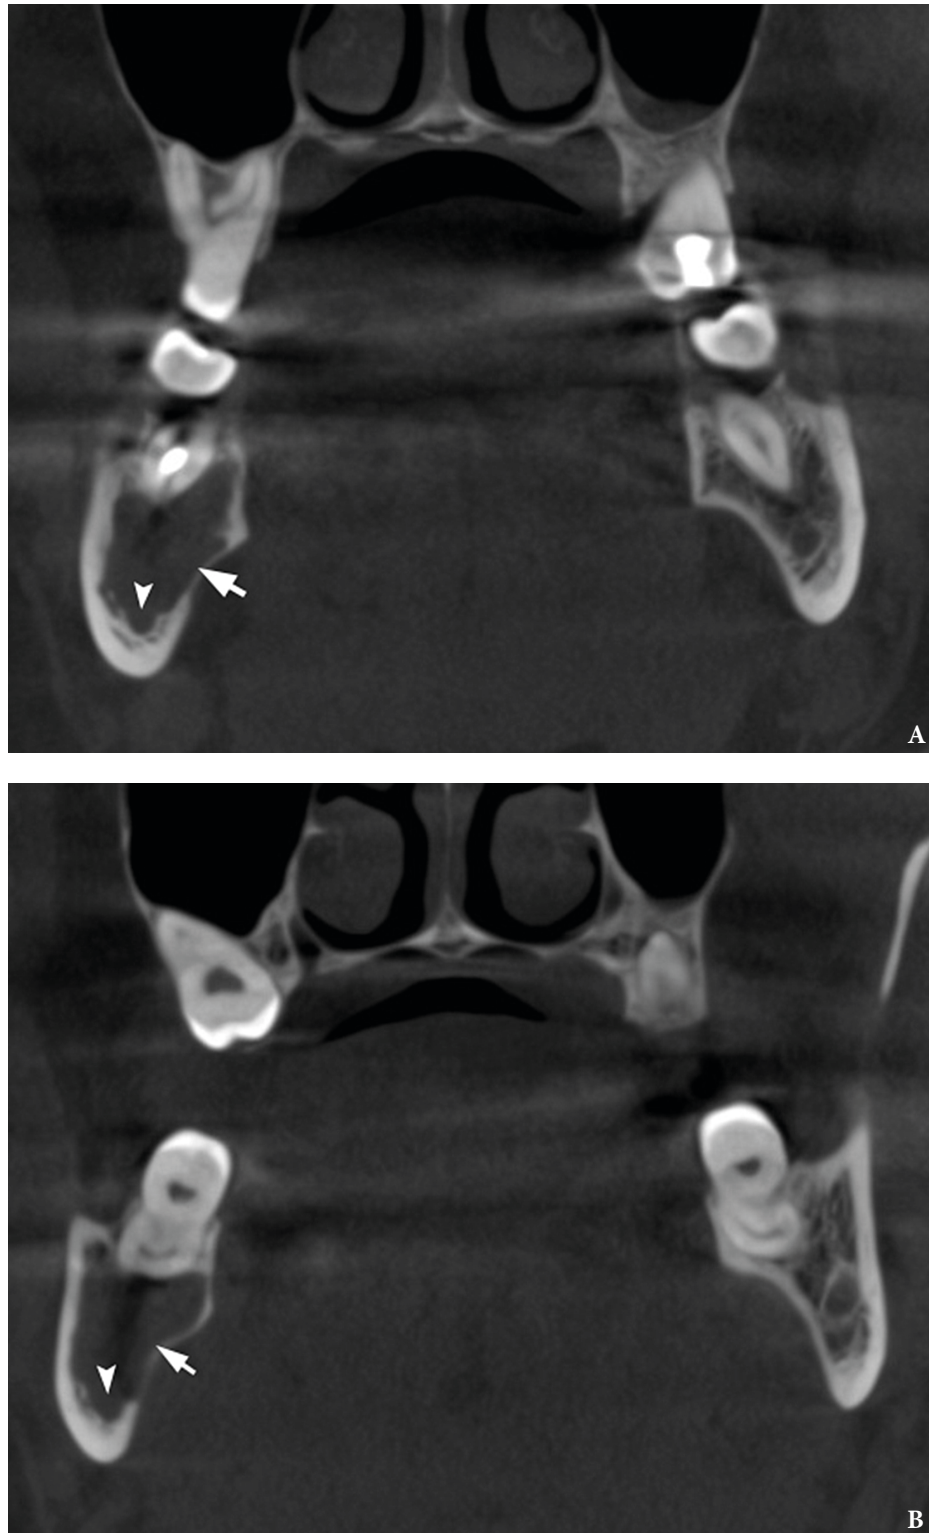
Cone beam computed tomography (CBCT). (A) Coronal scan at the level of teeth #46, 47 on the right and teeth #36, 37 on the left. Simple bone cyst is indicated by *arrow*. The neurovascular bundle (*arrowhead*) is pushed towards the inferior border of mandibular body. (B) Coronal scan at the level of tooth #48 on the right and tooth #38 on the left.
